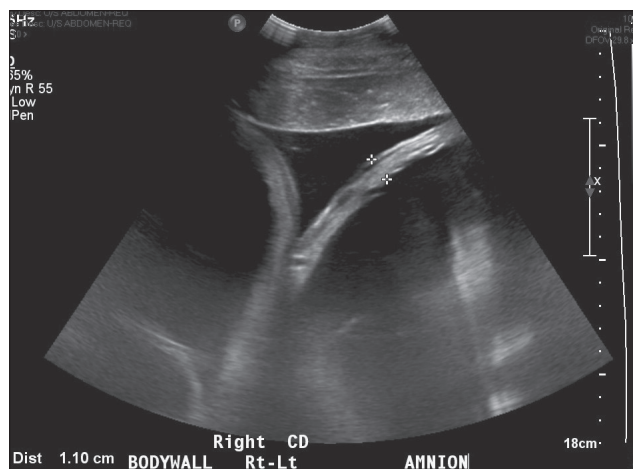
Transabdominal ultrasound image showing thickened amnion (1.1 cm).
